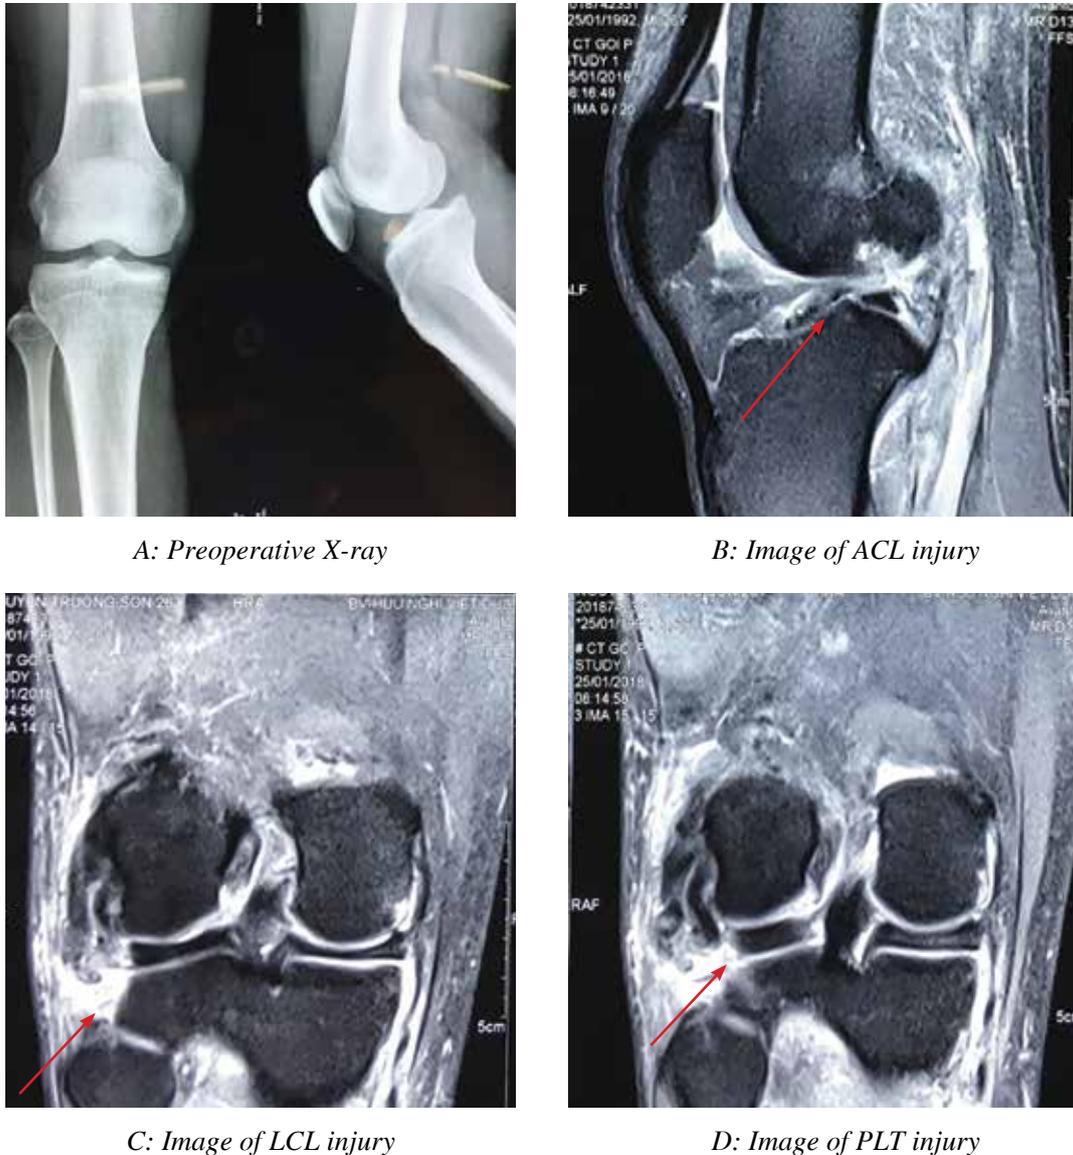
Preoperative injuries in Radiography examination
